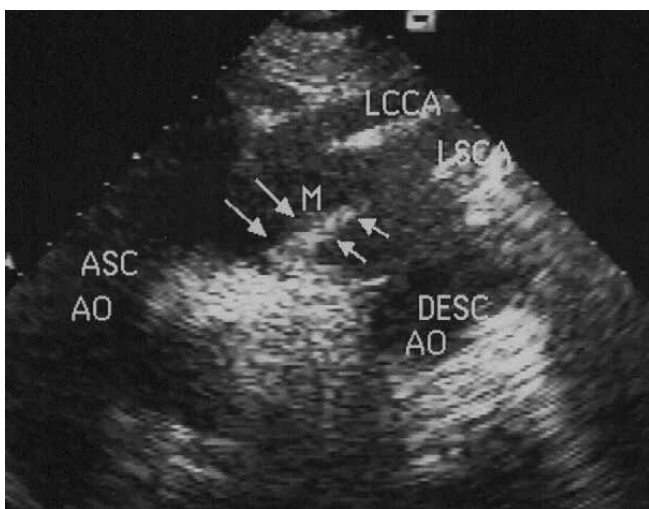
Transthoracic echocardiographic examination revealing a mobile atheroma at the aortic arch with minimal aortic dilatation. Asc Ao: ascending aorta, LCCA: left common carotid artery, LSCA: left subclavian artery, Desc Ao: descending aorta, M: mobile atheroma.
